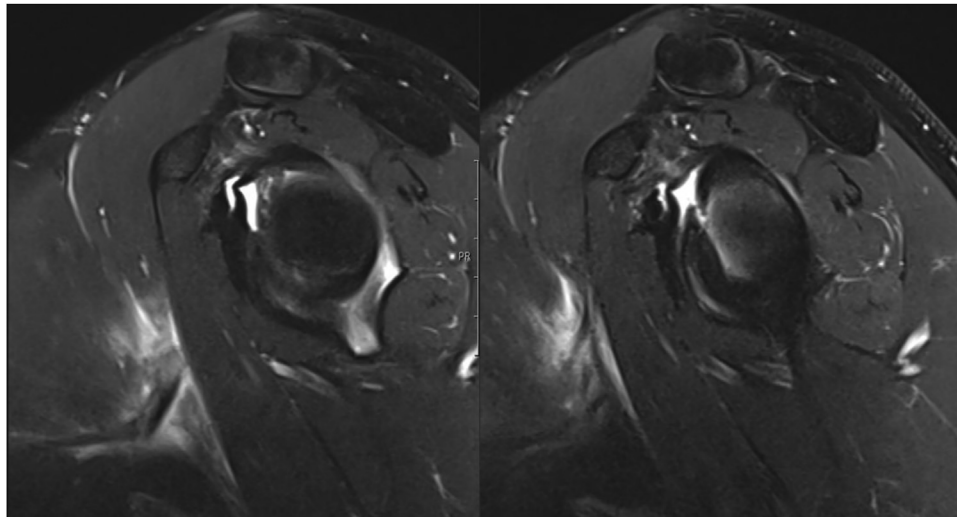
Axial T2-weighted MRI demonstrating pectoralis major tendon rupture with 3.5 cm medial retraction. MRI, magnetic resonance imaging.
